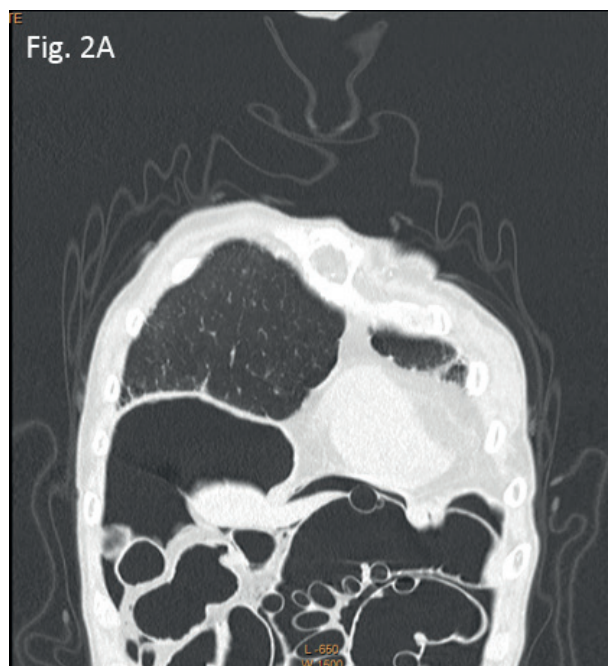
Abdominal CT scan reveals the exacerbation of pneumoperitoneum, dilated intestinal canals, and air-filled cysts of the walls.
